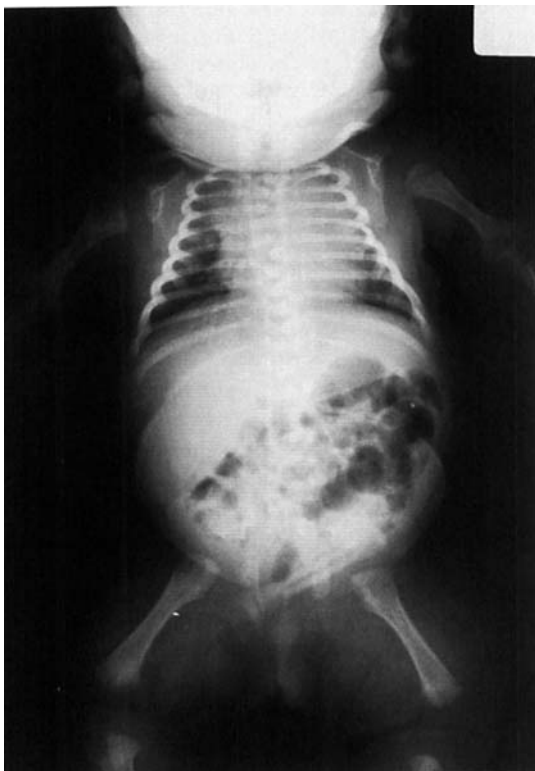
X-ray skeletal survey in the neonatal period.
